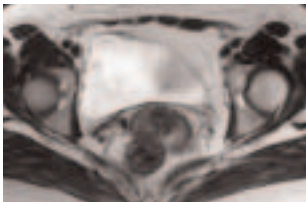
T1-weighted image.
